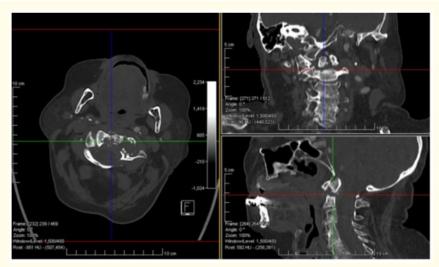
Native cervical CT scanner showing a C2 odontoid Alonzo-Anderson type 2 fracture in the axial plan (left image), coronal plan (upper right image) and sagittal plan (lower right image).
